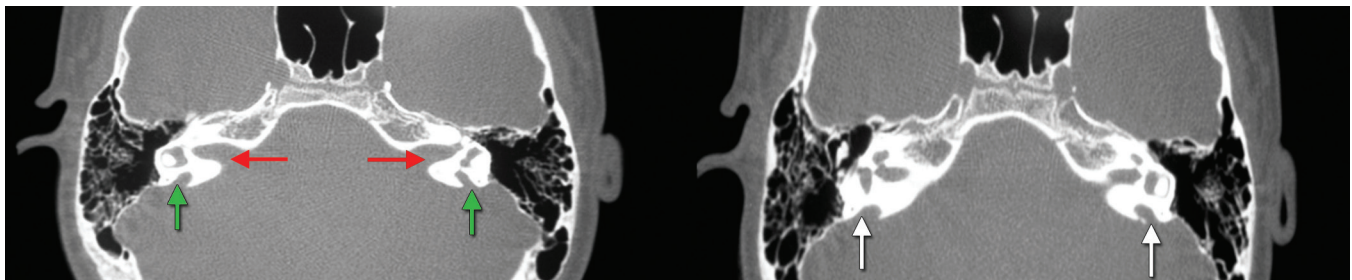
An axial CT scan shows bilateral enlarged vestibular aqueducts in (red arrows). Note the perpendicular orientation to the IAC shown in (green arrows). (IAC, internal auditory canal).
